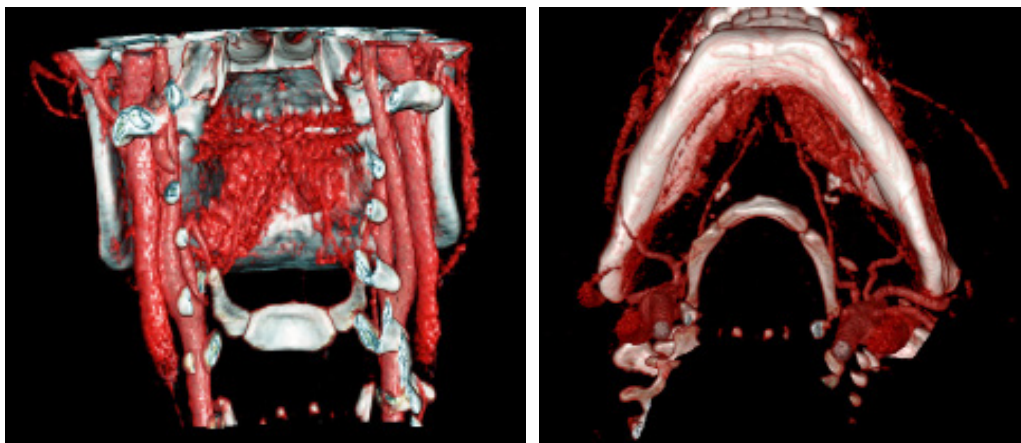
Fragments of computed tomography with vascular opacification of patient with recurrences of cavernous hemangioma of the mouth floor after several surgical interventions. Angioma residues of the left-sided localization are observed
